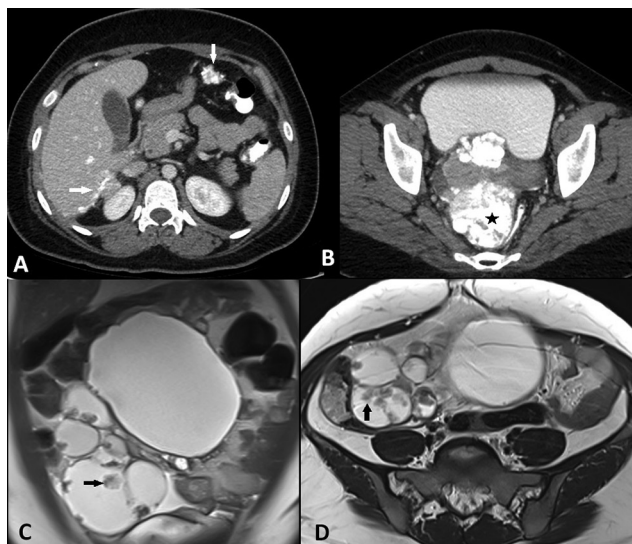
Imaging findings in low-grade serous carcinoma (LGSC) of ovary in two different patients. (A, B) CECT of 45-year-old patient 1 showing calcified peritoneal disease along the liver surface and the pelvis (*) and calcified omental nodules (arrows). (C, D) MRI T2 weighted images of a 32-year-old patient 2 with LGSC shows large complex cystic ovarian mass with irregular papillary solid components (arrows).
